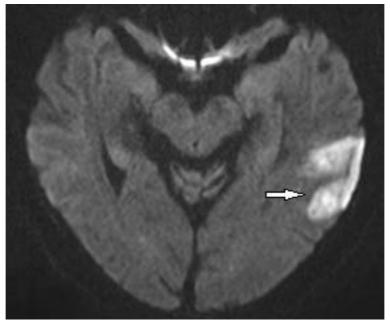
MRI axial diffusion-weighted image - high signal in the left cortico-subcortical temporal region.
